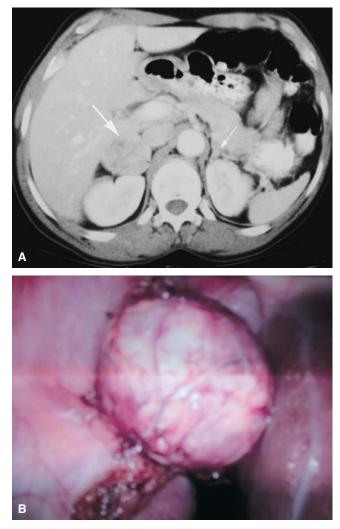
An abdominal computed tomographic scan performed in a 63-year-old woman because of mild right upper quadrant pain. *A*, The scan shows a 4 cm right adrenal tumor (*large arrow*) and a normal left adrenal gland (*small arrow*). B, Subsequent biochemical workup confirmed pheochromocytoma. The patient was α -adrenergic blocked, and the right adrenal tumor was resected laparoscopically. Courtesy of Quan-Yang Duh, MD.
